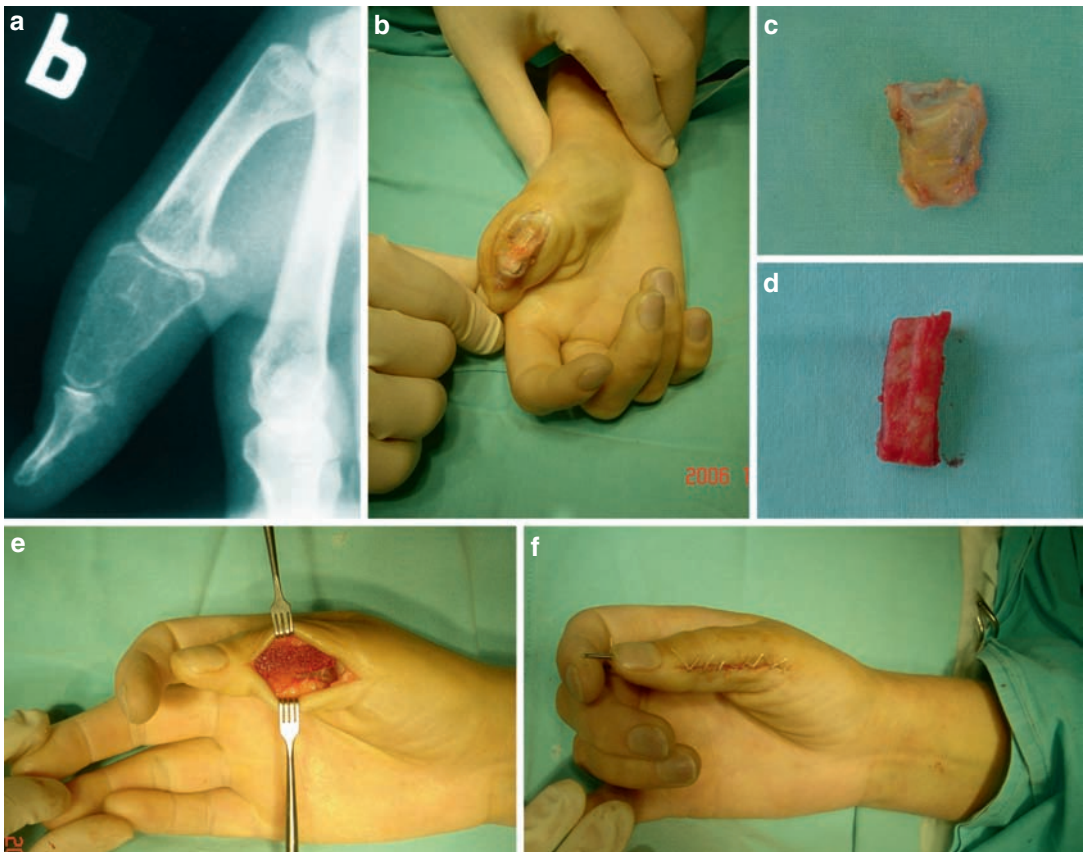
Giant cell tumor of thumb proximal phalanx. (a) X-ray. (b) Intraoperative view. (c) Excised tumor. (d) Bone graft. (e) Reconstructed phalanx. (f) Final appearance.
